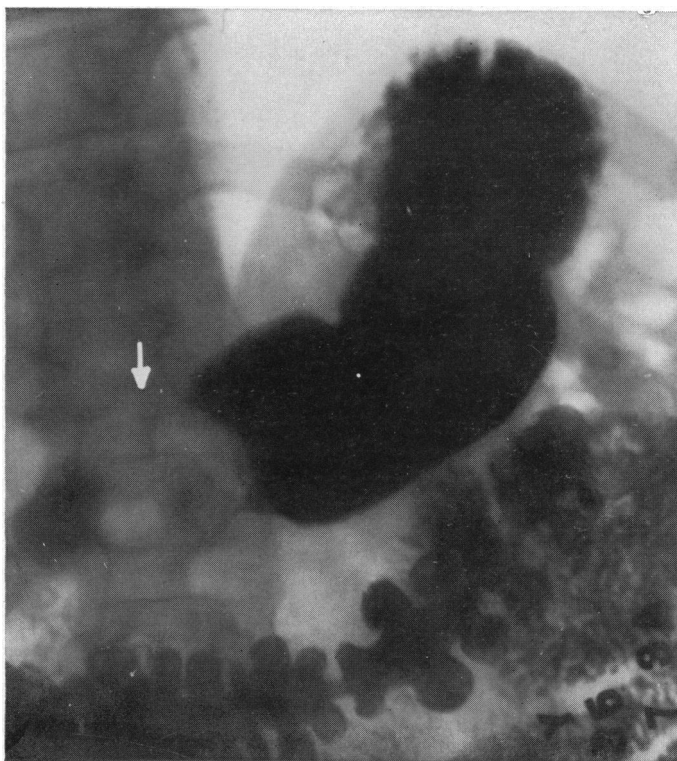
Case 1: Roentgenogram of the stomach showing the defect.
